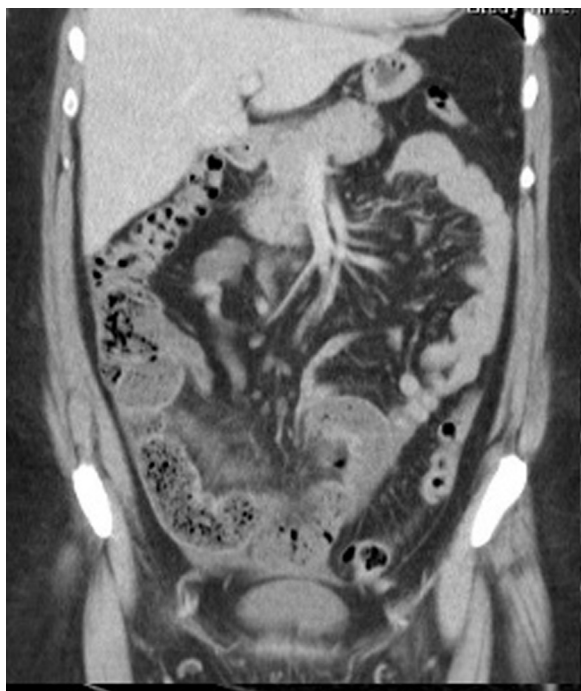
Coronal CT image demonstrating acute small bowel obstruction with a transition point and faecalisation within the distal ileum.
